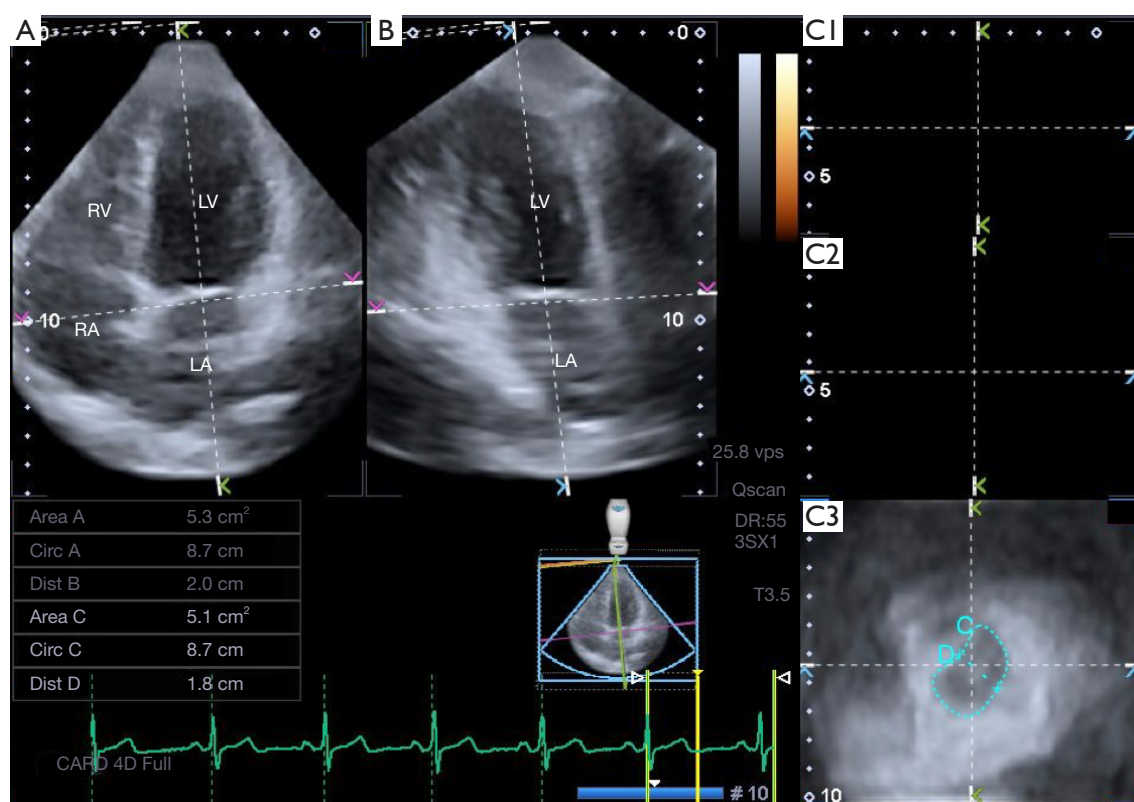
Images from three-dimensional full-volume echocardiographic dataset: apical four-chamber view (A), apical two-chamber view (B) and a cross-sectional view at the level of the mitral annulus (C3) optimized on apical four- and two-chamber views. (C1,C2) Cross-sectional views of different LV levels, not shown during MA measurements. Mitral annular data in end-systole and end-diastole are also presented. Area, MA area; Circ, MA perimeter; Dist, MA diameter; LA, left atrium; LV, left ventricle; RA, right atrium; RV, right ventricle.
